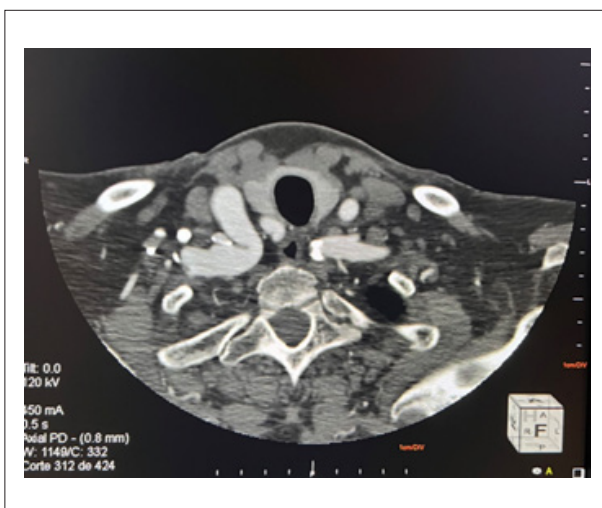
Computed tomography of the skull and neck showing right subclavian artery kinking.
